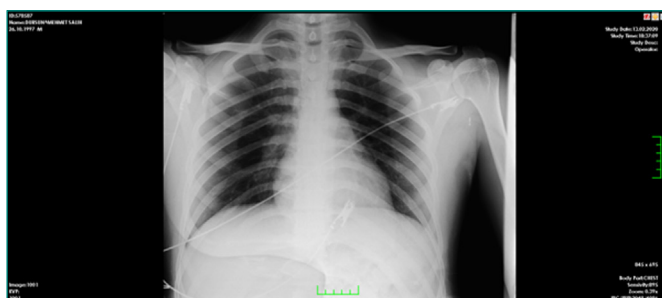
Postoperative fourth day PA chest X-ray.
